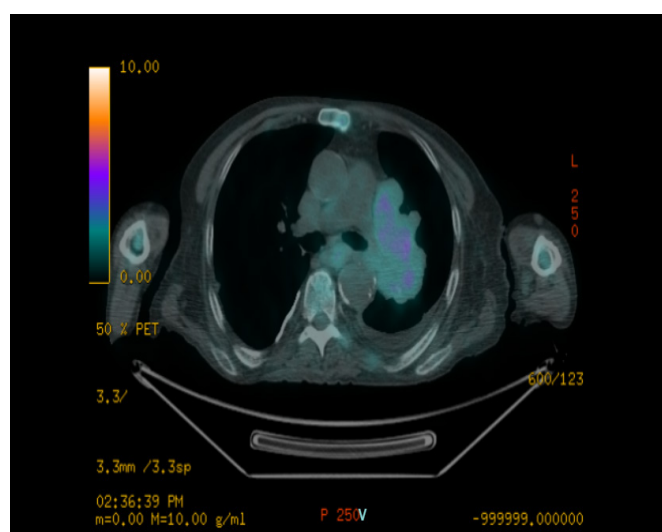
PET/CT cross-section
